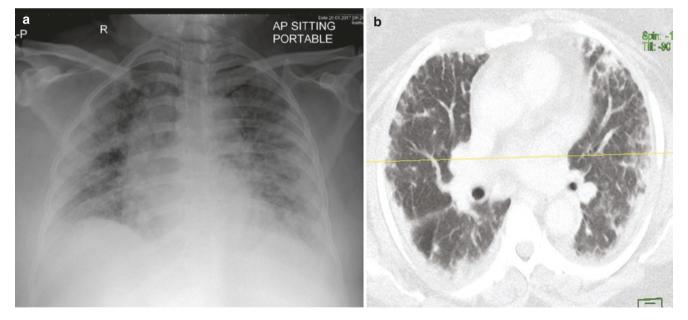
Idiopathic chronic eosinophilic pneumonia (ICEP) in a 54-year-old woman with childhood asthma presenting to emergency department with acute onset dyspnea. (a) A-P chest radiograph shows
